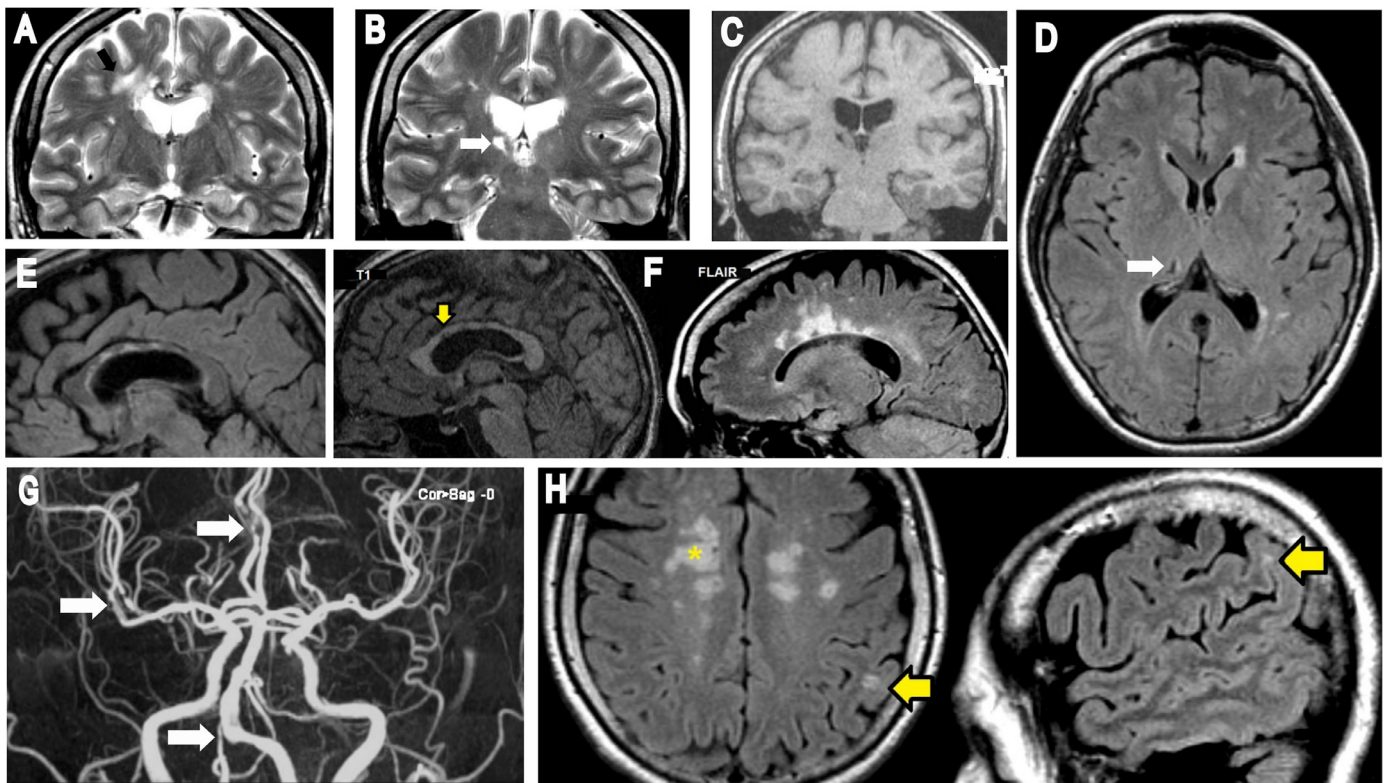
MRI of the Brain with and without contrast. Panels A-B show coronal views demonstrating confluent T2 hyperintense lesions involving the periventricular white matter, mainly on the right side, which extend to the juxta-cortical region (black arrow). These images also reveal substantial atrophy of the corpus callosum and neighboring cerebral cortex. The white arrow in panel B points to a small fluid-filled lesion involving the right thalamus; Panel C provides a T1 coronal view of this lesion, while Panel D demonstrates a hyperintense rim on FLAIR indicating perilesional gliosis (white arrow), which is consistent with a lacunar infarct. Panel E shows T2 hyperintense lesions in the corpus callosum on sagittal FLAIR. Panel F shows indentations of the corpus callosum on T1 sequences (arrow), while the FLAIR sequence on the right shows typical Dawson fingers. Panel G shows multifocal intracranial stenosis (white arrows), predominantly involving the right A2, right MCA branches, and right intradural vertebral artery. Lumen irregularity suggests that atherosclerosis is the underlying etiology. Panel H again shows juxta-cortical lesions (arrows) on sagittal FLAIR involving the left parietal lobe, while the asterisk marks another instance of Dawson fingers extending into the centrum semiovale on the right side.
